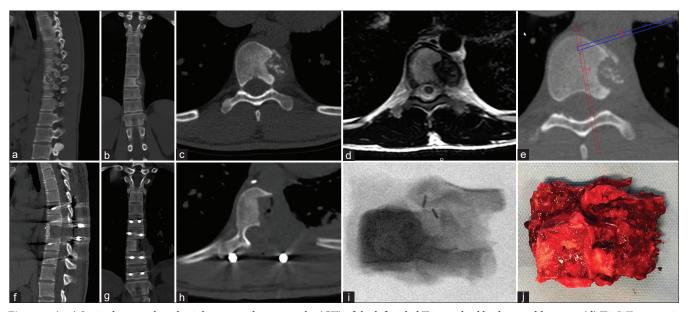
(a-c) Sagittal, coronal, and axial computed tomography (CT) of the left-sided T9 vertebral body osteoblastoma. (d) T2-WI magnetic resonance imaging of tumor's proximity to aorta, lung, and cord. (e) Preoperative multiplanar osteotomy planning. Red cut - first-step transthoracic approach; blue cut - second-step posterior approach to release the tumor en bloc. (f-h) Postoperative CT images demonstrate complete tumor resection. Images i and j show surgical sample of tumor in the left posterolateral T8 vertebral body surrounded by the T7 and T8 rib heads and soft tissue.
